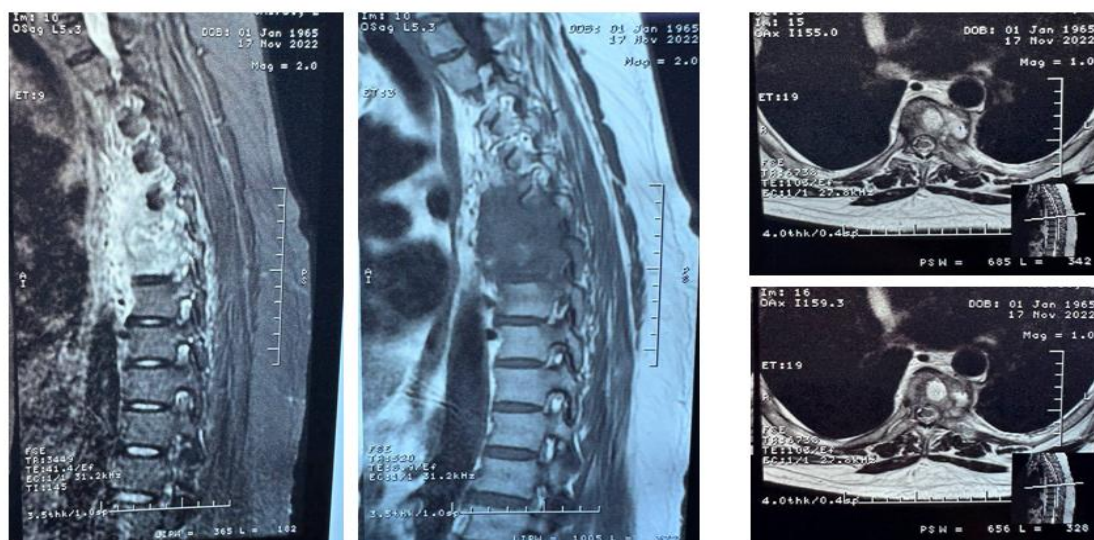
MRI images of the thoracic vertebrae
